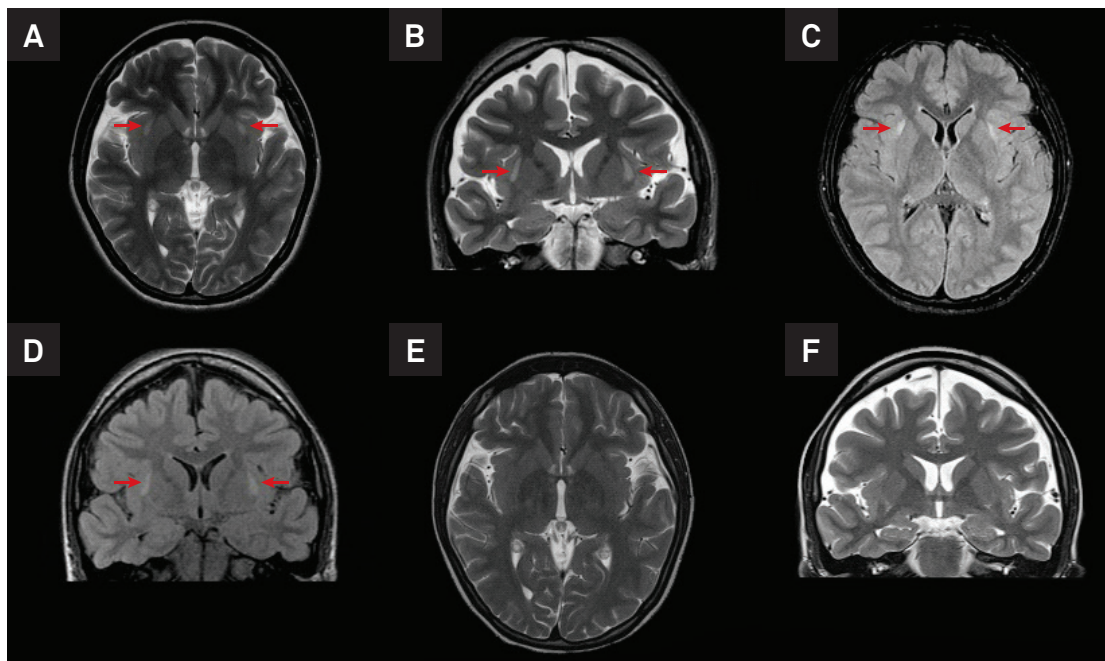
Axial (A/C) and coronal (B/D) T2-weighted and FLAIR MRI sequences – hyperintensities in bilateral external capsules and claustrum. Diffusion-weighted MRI images were unremarkable. Axial and coronal T2-weighted (E/F) MRI sequence showed no abnormalities at the four-month follow up.
